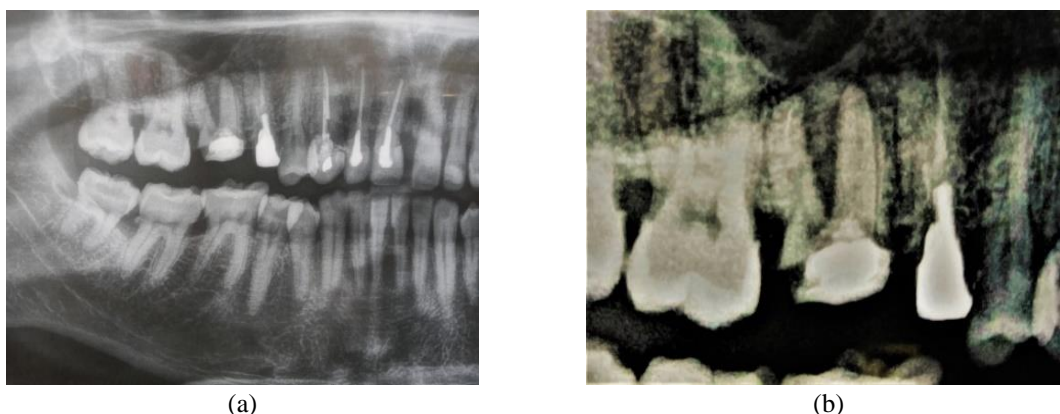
Initial panoramic radiography (a) original panoramic and (b) structure of interset
